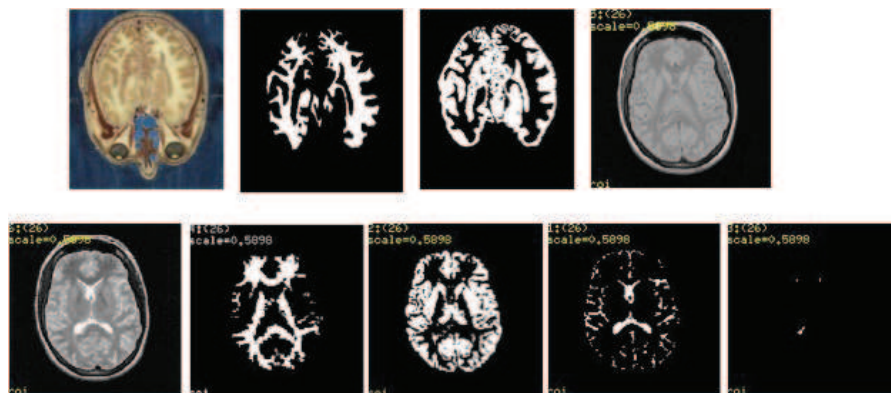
FC and AFC segmentation of brain images. Top: Cross-sectional brain image from visible woman data set, white and gray matter segmentations via vectorial scale-based FC, and proton density weighted MRI; Bottom: T2 weighted MRI, white matter, gray matter, CSF and lesion segmentations via AFC.
